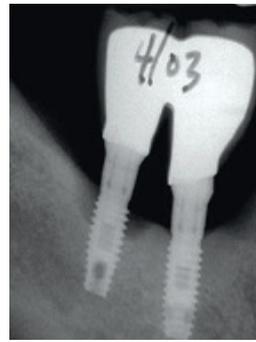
A 2003 radiograph demonstrating crestal bone loss about the distal implant to the fourth thread.
